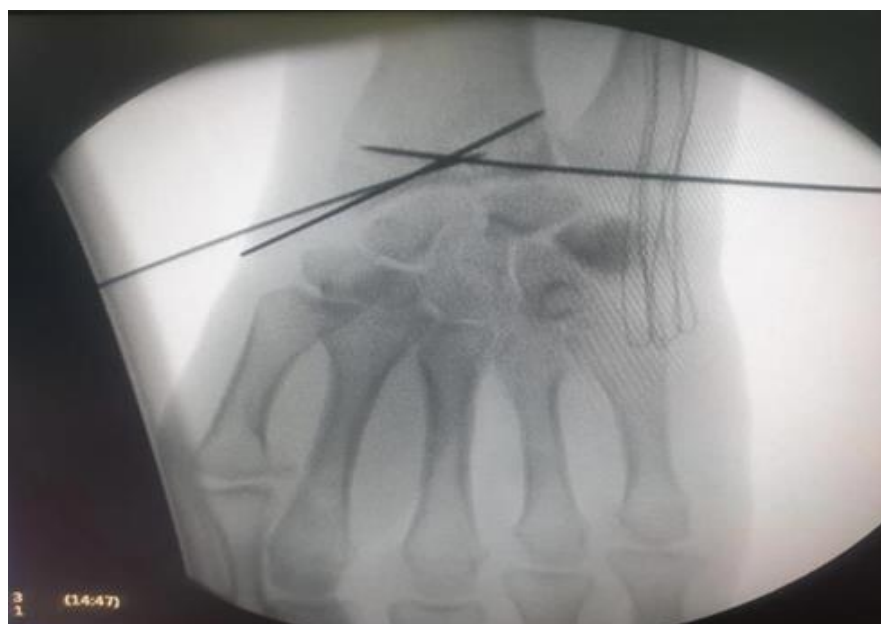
Intra-operative antero-posterior plain x-ray showing reduction of dorso ulnar fragment by K- wires
